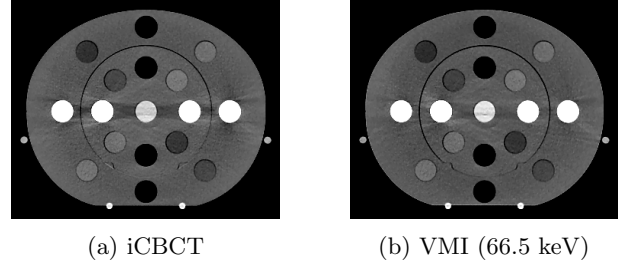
Beam hardening artifact near bone plugs is reduced in the VMI from polychromatic reconstruction (right) as compared to an iCBCT reconstruction (left).  $W/L = 500/75$  HU
